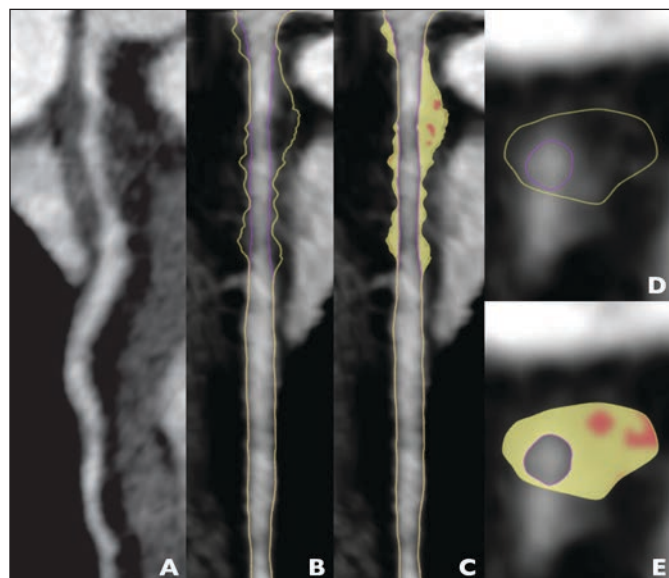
40-year-old patient who presented with myocardial infarction without ST elevation and underwent coronary CTA. Patient had coronary artery calcium score of 0. Patient had acute coronary syndrome develop 8 days after coronary CTA was performed. Invasive coronary angiography identified culprit lesion in proximal left anterior descending (LAD) artery.
